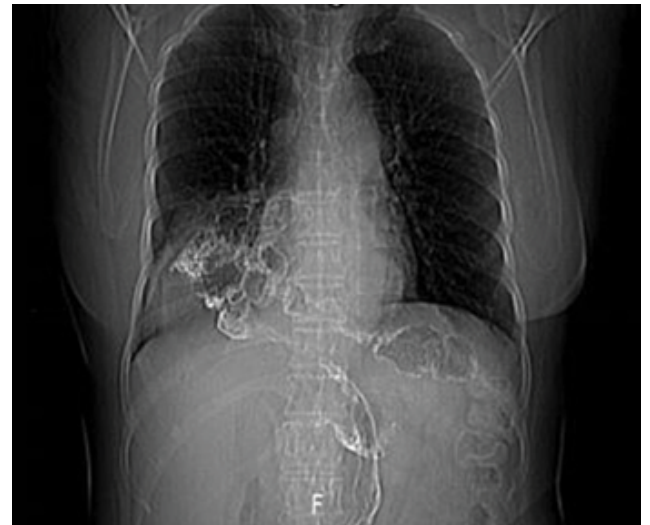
Chest radiography, a giant air-barium shadow in the right chest.
